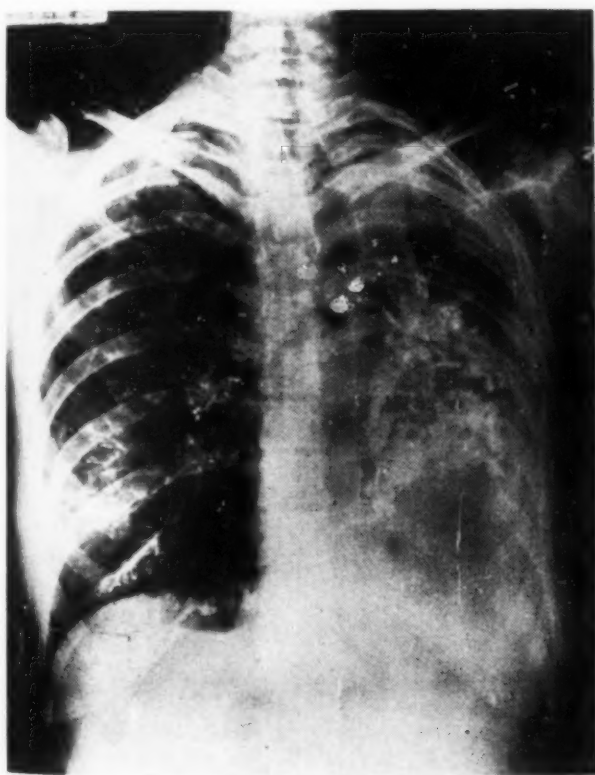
Roentgenogram of chest of a woman, aged 36 years, who has pulmonary tuberculosis with cicatricial stenosis of the left main bronchus, collapse of left lung with retraction of trachea to left and evidences of bronchiectasis of lung. Bronchoscopic dilation of the stricture and aspiration of pus gave temporary benefit but the patient did not wish to continue treatment. With irregular fever, sweats, pain in left chest and increasing dyspnea the prognosis is unfavorable.
